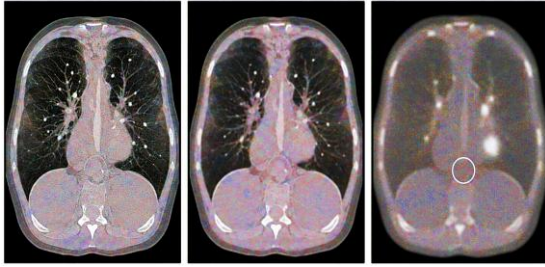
Lung CT slices (mean curvature flow).
